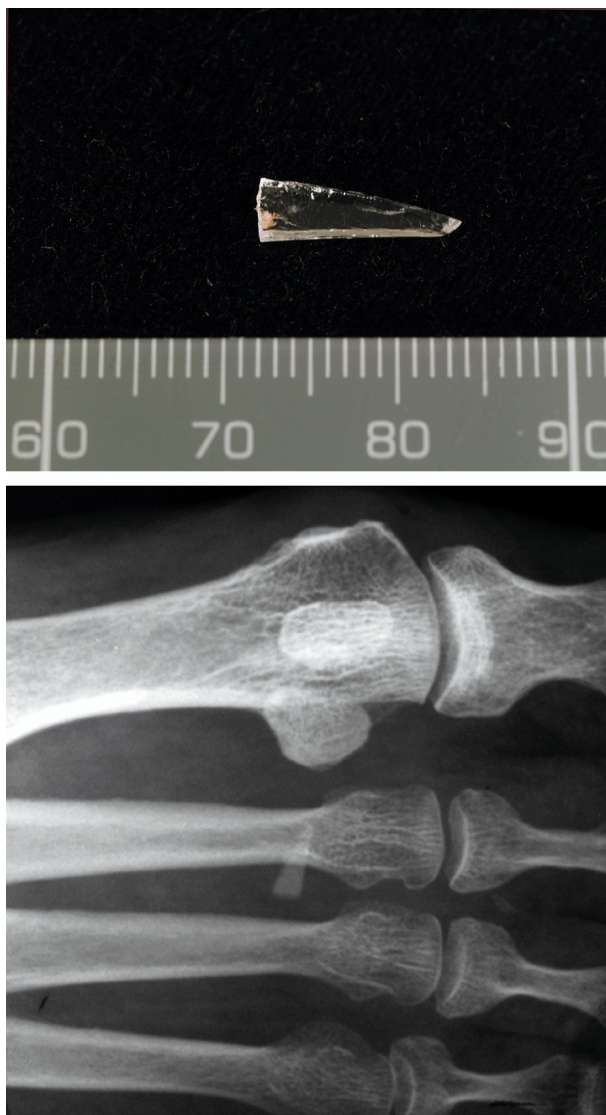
Shard of glass (A) removed from sole of a patient's foot and (B) radiograph of foot showing shard before removal
